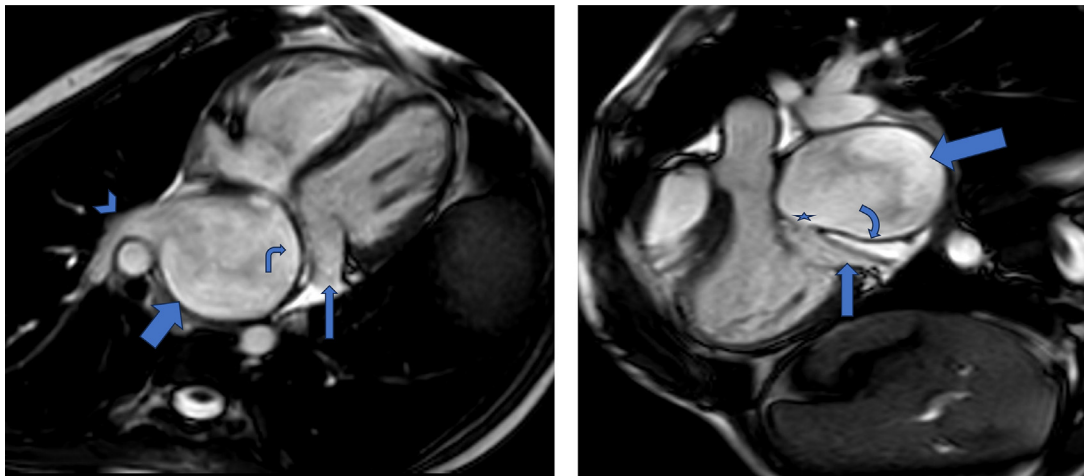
Two images of cardiac MRI, balanced turbo field echo (BTFE) sequence, axial and sagittal views, show a fibromuscular membrane (curved arrow) with internal fenestration (star), dividing the left atrium into 2 chambers, a proximal chamber (thick arrow) containing the pulmonary veins (arrowhead), and a distal chamber “true” left atrium (thin arrow) containing the left atrial appendage.
